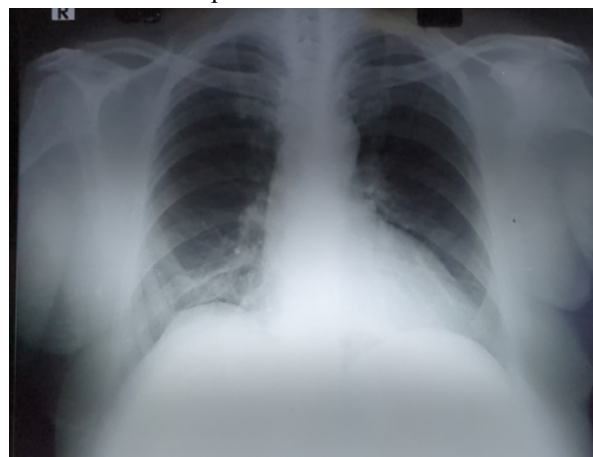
a) Chest X-ray PA view at presentation. b) & c) Bronchoscopy performed at presentation.
